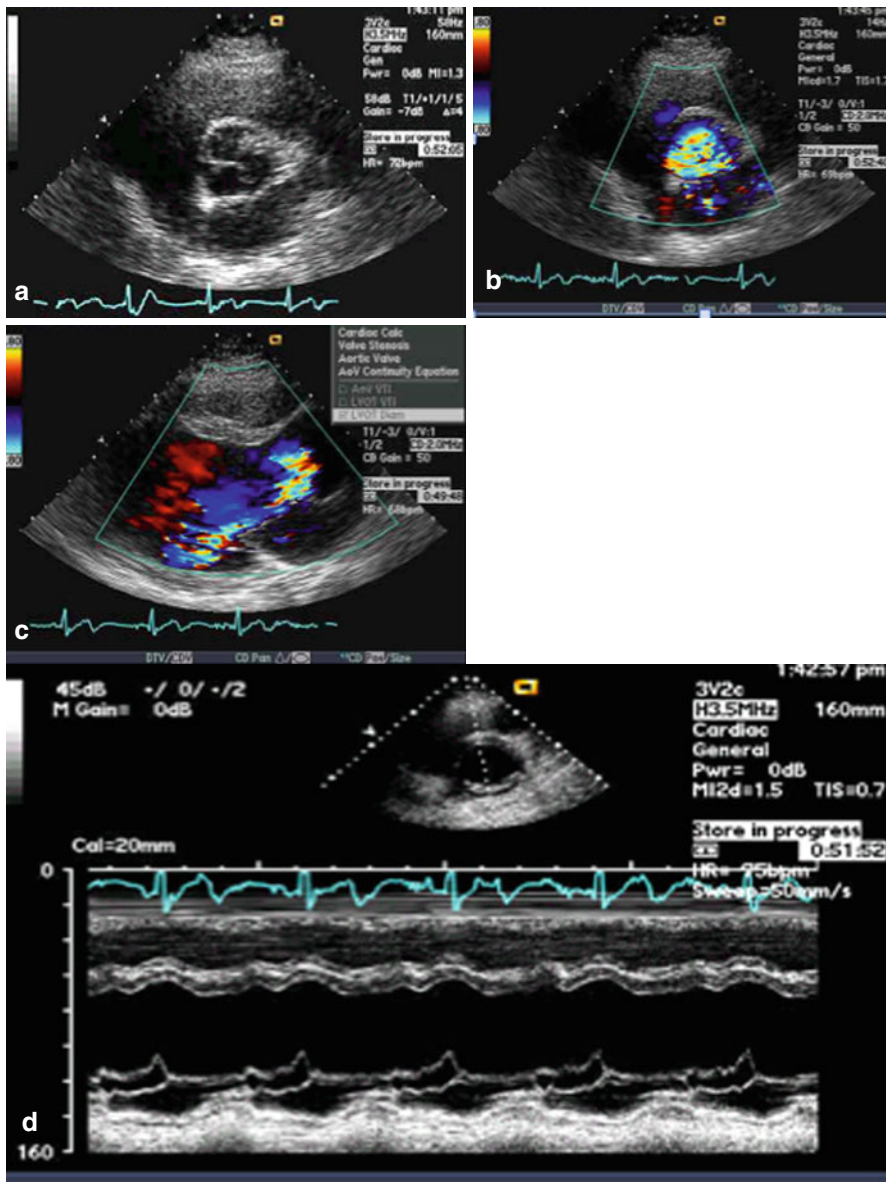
(a–d) Echocardiograms. (a) An abnormal valve with deformed left coronary leaflet. (b) Severe aortic regurgitation on color Doppler. (c) The AR jet courses along the anterior mitral leaflet. (d) Fluttering and early closure of the mitral valve is shown on M-mode
